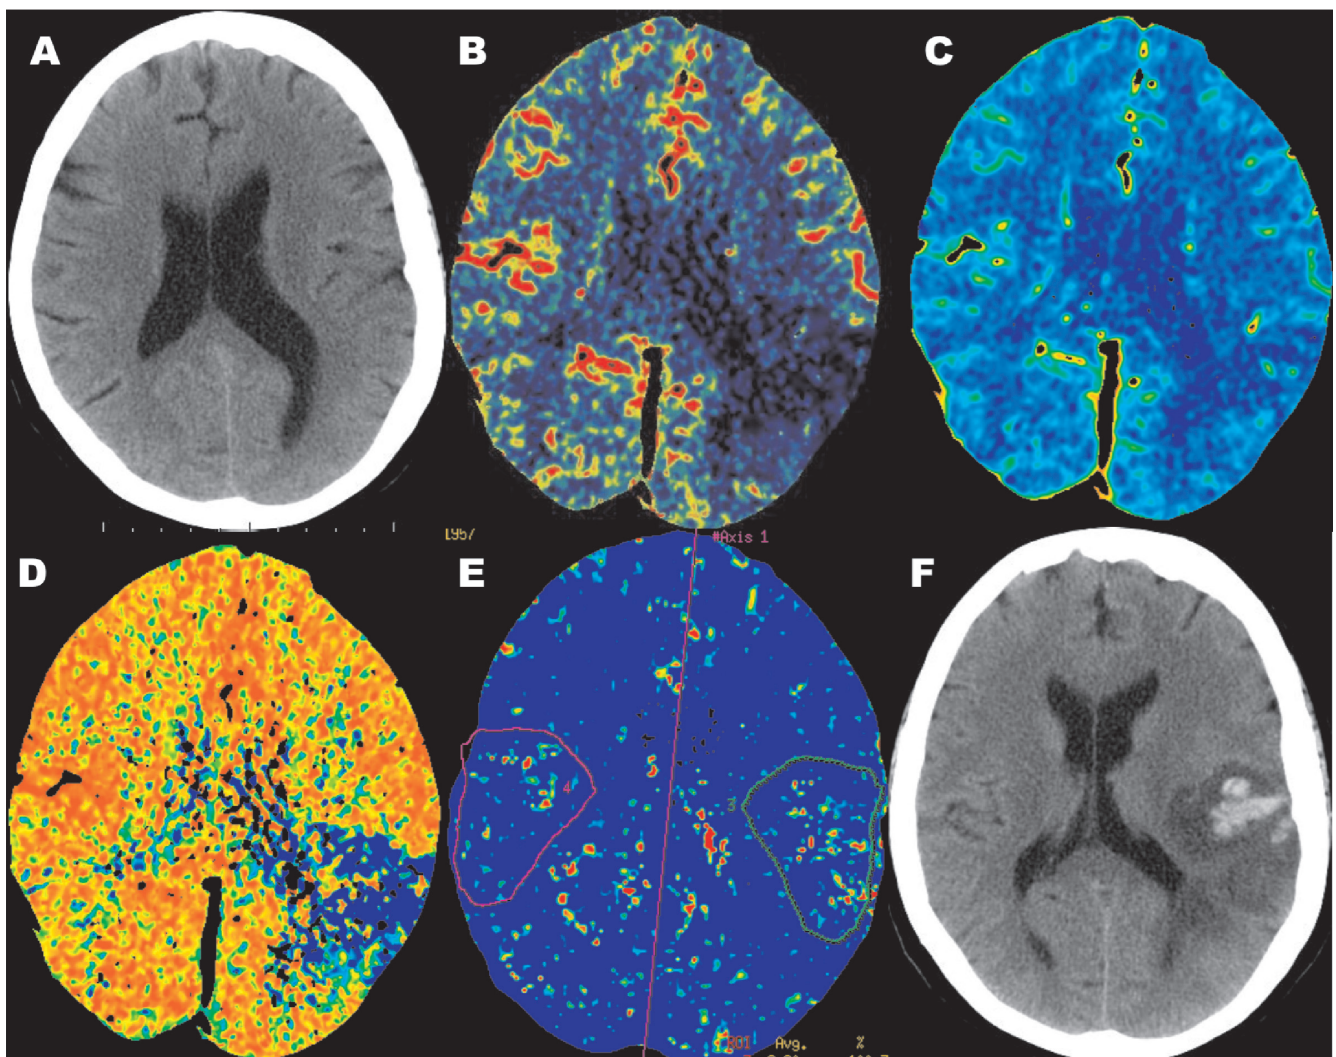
Female, 57 years, acute (2 hour from the symptoms onset) ischemic stroke in left middle cerebral artery circulation territory. CT perfusion functional maps. A - non-contrast CT, there is no evidence of abnormalities, B - CBF, C - CBV, D - MTT, E - permeability surface area product (PS), F - non-contrast CT 26 hours after symptoms onset, hemorrhagic transformation, parenchymatous hematoma type 2.
